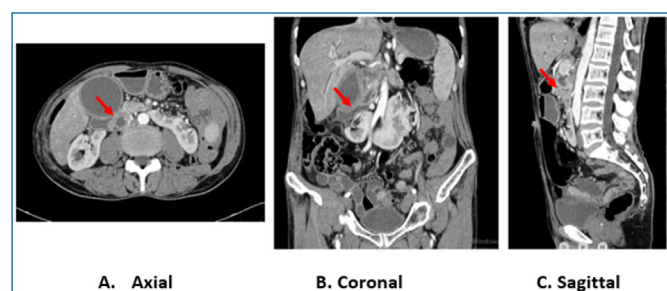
IV contrast-enhanced computed tomography (CT). The PADD is indicated by the red arrow at the A. Axial, B. Coronal, C. Sagittal
